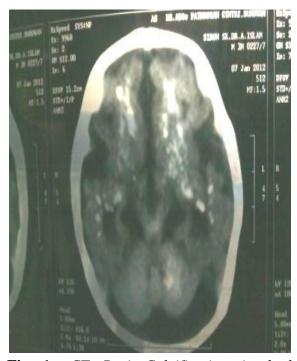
CT Brain-Calcification in both cerebral hemisphere, mainly in Dentate nuclei, mid brain, caudate nuclei, thalami, putamina, globus pallidi & periventricular region B/L. Both lateral & 3rd ventricles were dilated, with wide extra axial CSF space.
